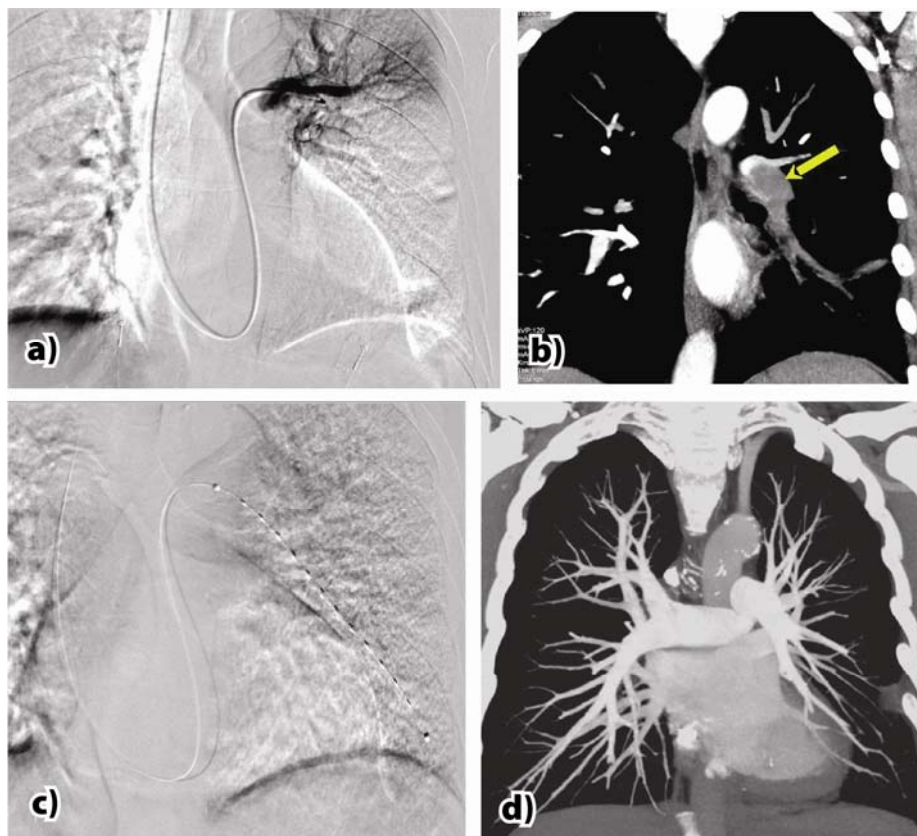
a) and b) Thrombus in the left pulmonary artery; c) EkoSonic™ device; d) Final multidetector computed tomography with pulmonary angiography.
